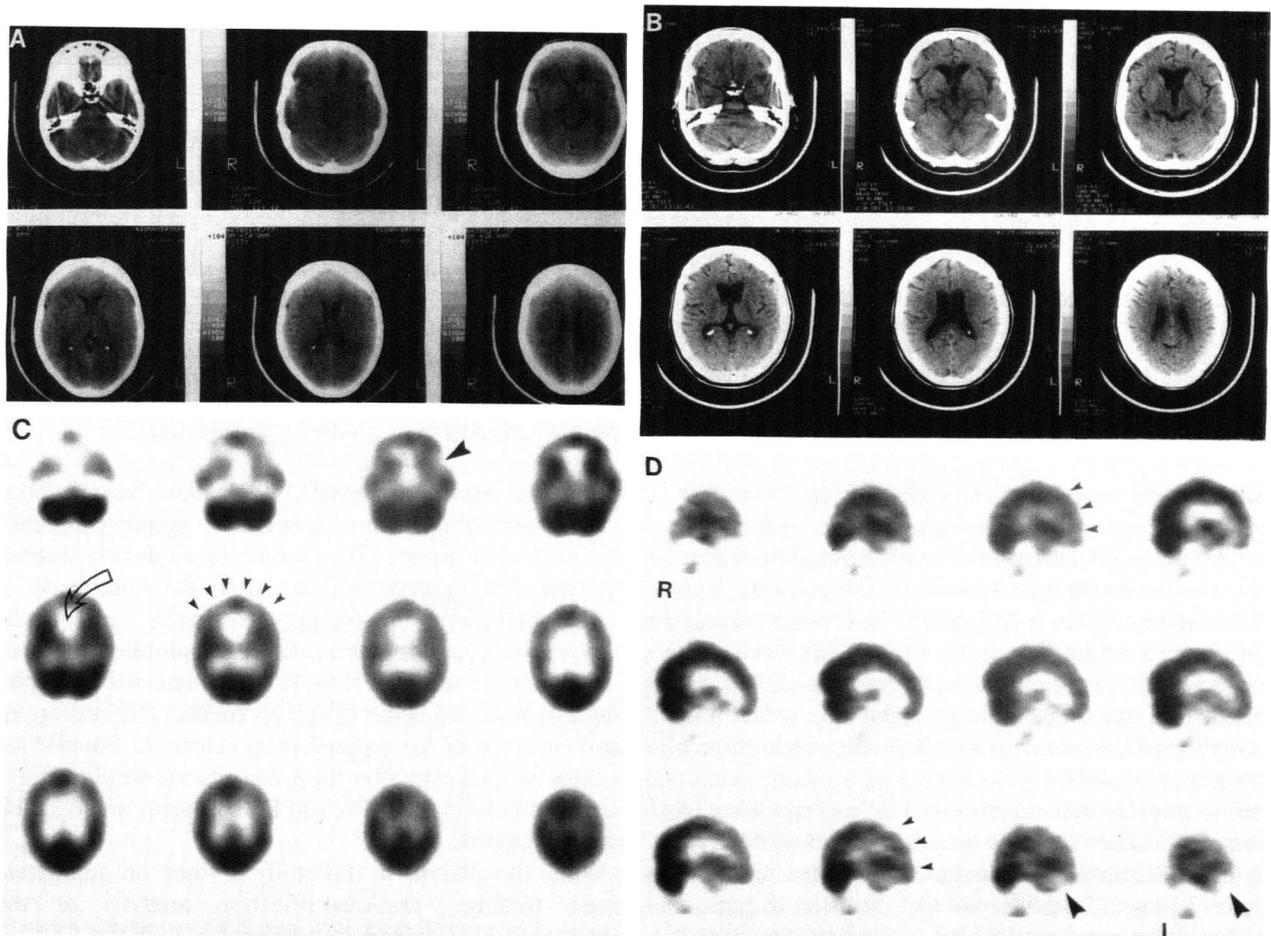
A 37-yr-old female who suffered a major head injury during a motor vehicle accident. The patient struck her right periorbital region with resultant intermittent coma (PTA = 7 wk). Current symptomatology: decreased memory, indecision, and noise intolerance with hyperacusis. (A) Selected images from CT at time of trauma show an intracranial contusion in the right inferior frontal lobe. (B) Selected images from a repeat CT, 27 mo after trauma, reveal atrophic changes in the frontal and temporal lobes bilaterally. HMPAO SPECT images, (C) transaxial and (D) sagittal, obtained at same time as second CT (27 mo). Diffusely decreased perfusion of the cortex of the frontal and temporal lobes bilaterally (small arrowheads). In addition, there is decreased perfusion in subcortical region anteriorly (curved open arrow). A focal region of decreased cortical perfusion is present in the left inferior frontal lobe (large arrowheads).
